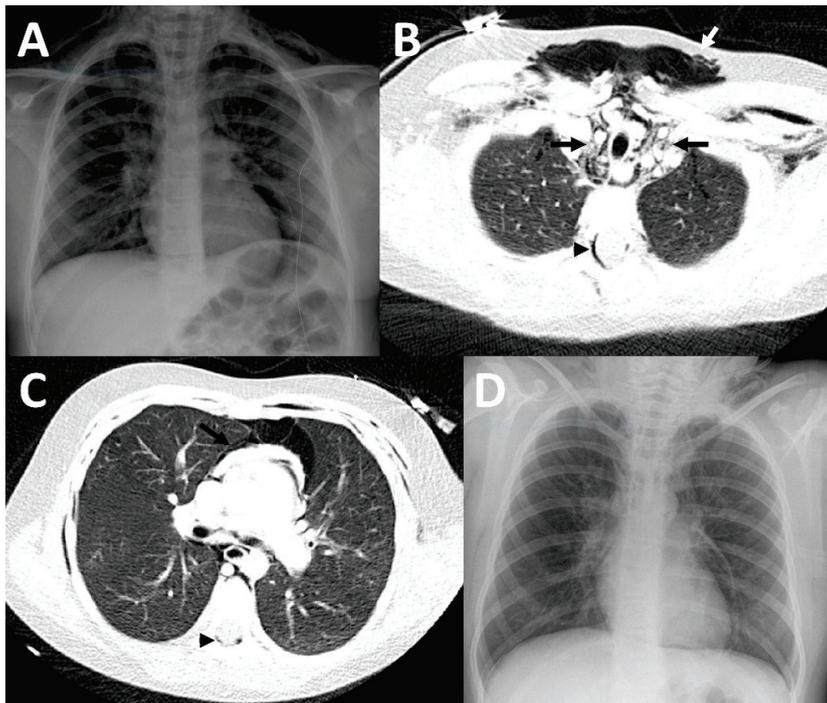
Imaging findings in patient 3. In the initial chest X-ray, pneumopericardium was suspected (A). Therefore, a CT was performed (B,C) which showed a pneumomediastinum (black arrows), accompanied by a large subcutaneous emphysema (white arrow) and epidural pneumatosis (black arrowhead), but no pneumopericardium. A chest X-ray (D) which was acquired at discharge showed substantial improvement of the previously mentioned findings.
